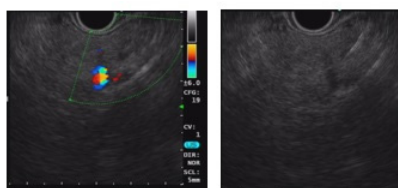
On EUS examination, a 1.5cm-sized oval shaped hypoechoic mass with central cystic component was noted at pancreas body with early arterial enhancement after peripheral injection of microbubble ultrasound contrast agent (SonoVue®).
